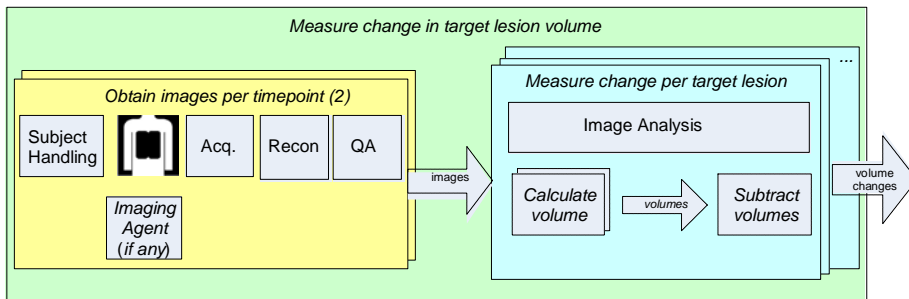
CT Tumor Volumetry – Activity Sequence
